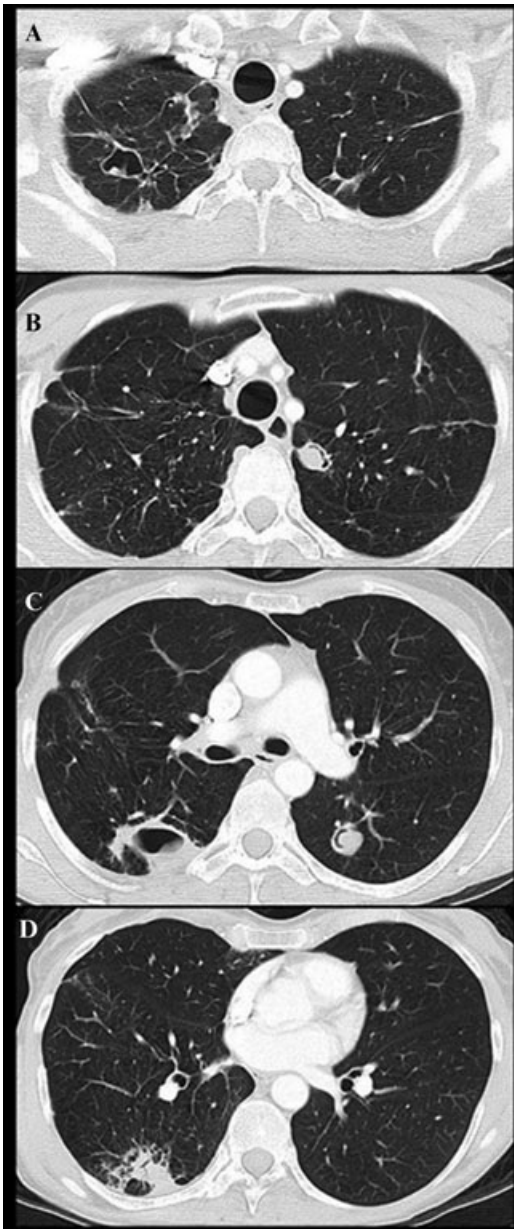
Patient 5. Four CT thorax sections in September 2010 showing four cavities, two containing aspergillomas. The highest section (A) shows a right sided thin-walled cavity with a small amount of material probably adherent posteriorly to the wall. (B) A second cavity on the left side medially almost completely filled with a fungal ball and an air crescent sign. (C) Two further cavities, one on each side, with that on the left with a slightly thicker wall and also almost completely filled with a fungal ball, with an air crescent sign. On the right, posteriorly abutting the pleura, is a thick-walled cavity with associated pleural thickening and two small areas of consolidation laterally. (D) The right-sided cavity is shown to extend several centimeters inferiorly, and change its shape slightly, but without intracavitary material.
